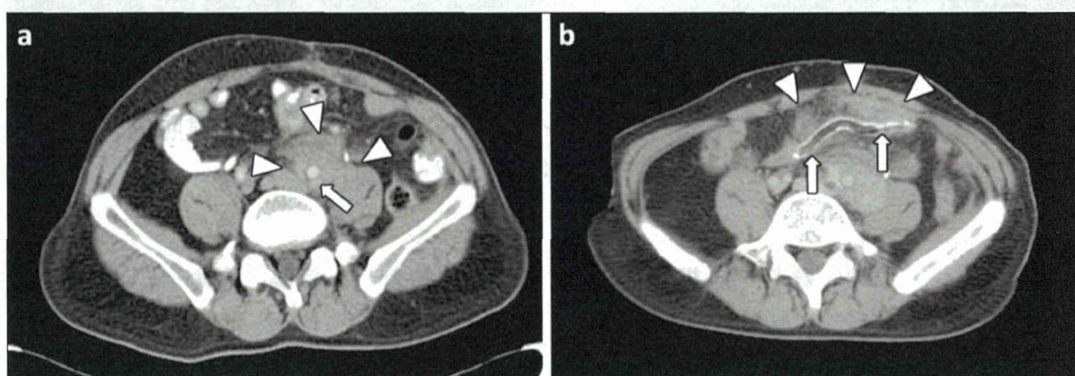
a: Abdominal CT at the initial consultation showed the tumor located ventral to the lumbar vertebra (arrowheads) encasing the left common iliac artery (arrow). b: Abdominal CT after the operation showed the Goretex sheets (arrows) retaining a sufficient distance between the tumor and the small intestine (arrowheads).
